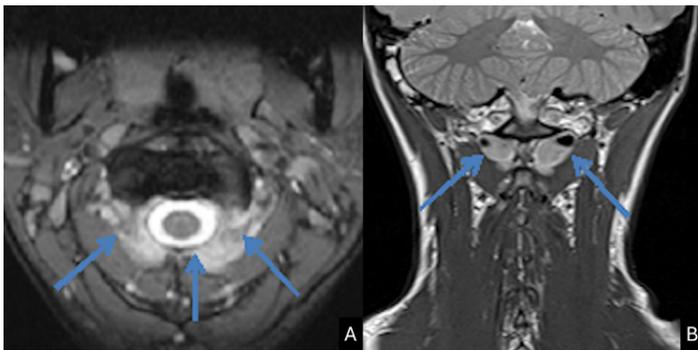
Incidental prominent suboccipital cavernous sinus and venous plexus. Axial T2-weighted image (A) and coronal proton density (B) images show a well-defined region of heterogeneous hyperintensity (blue arrows) between the posterior elements of C1 and C2.
